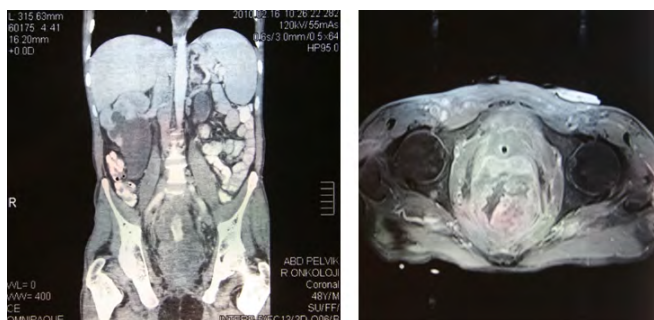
The view of coronary and sagittal plane in an MRI examination.
